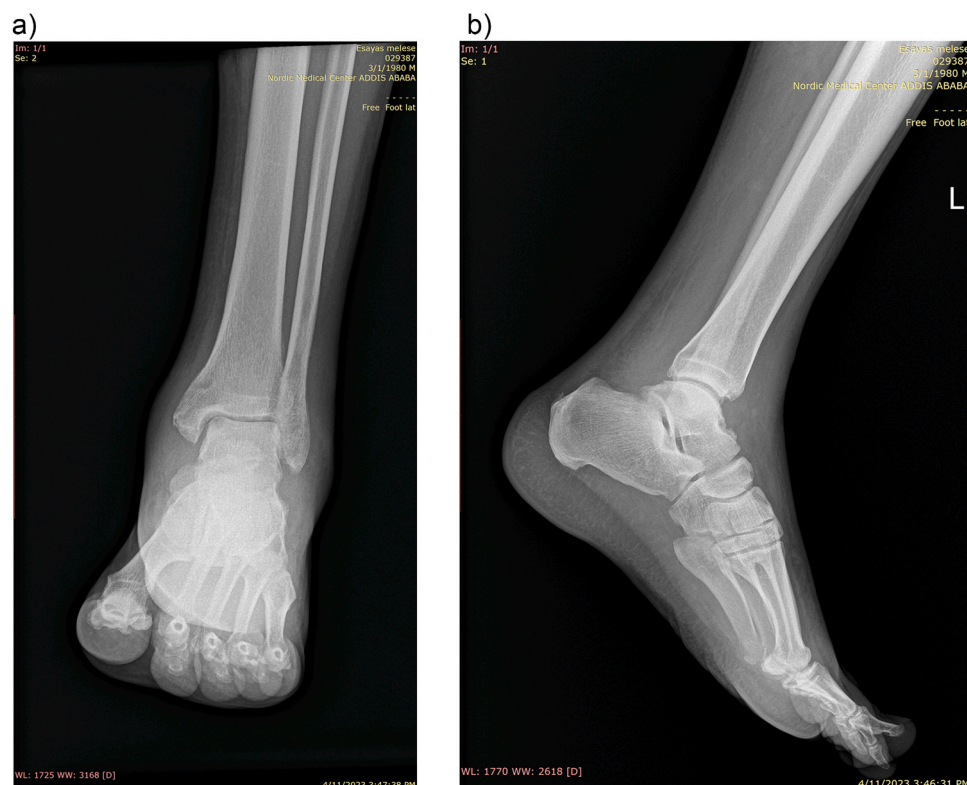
Ankle X-ray obtained on first presentation of the patient which showed signs of joint arthritis with tibia periosteal reaction. a) AP view. b) Lateral view.
